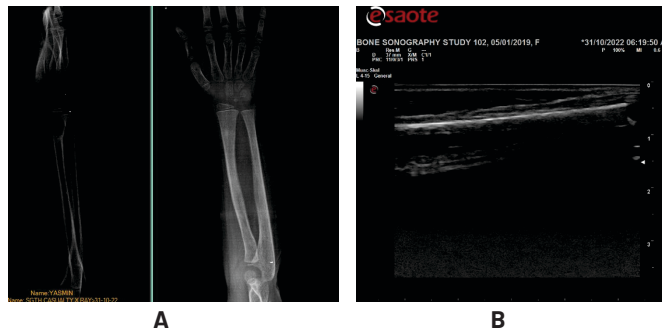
A: a kink is present in the radiograph B: no sonographic buckling
